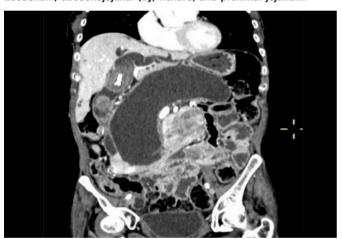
CT coronal reformatted image showing massively dilated pancreatic duct and common bile duct with internal encrusted stent. Bulky heterogeneously enhancing mass conforming the contour of the duodenum and duodenojejunal (DJ) flexure.
